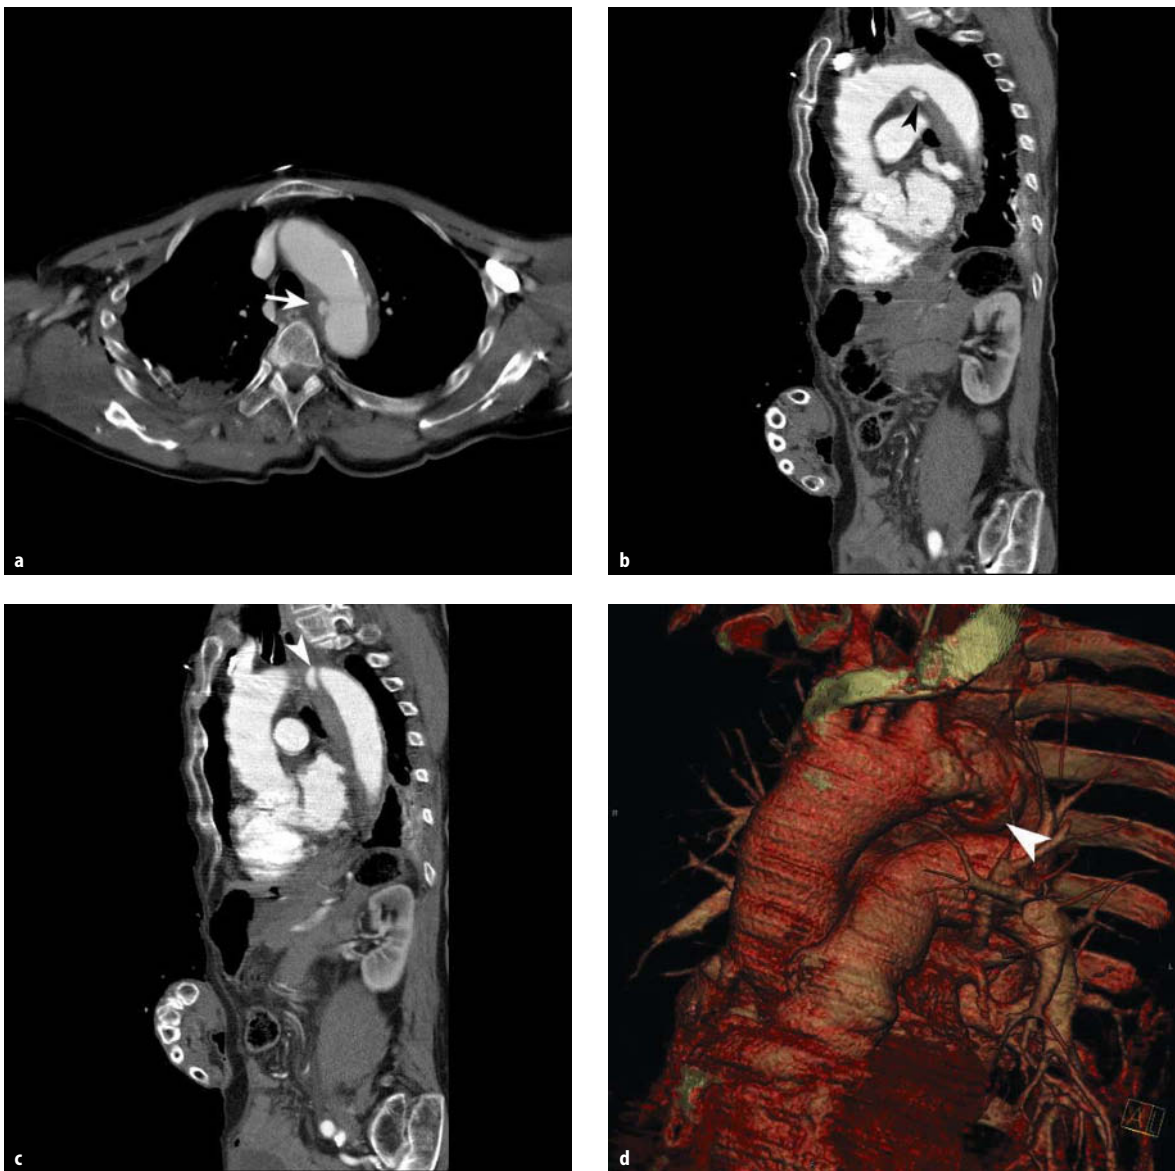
a Axial CT of a patient after deceleration trauma demonstrating extravasation of the contrast medium at the level of the aortic arch (*arrow*). b Sagittal oblique MPR demonstrating aortic rupture at the inner curve of the aortic arch, at the level
